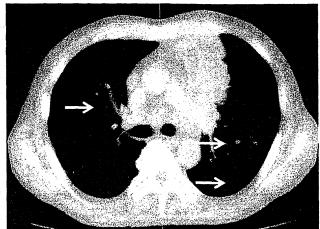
Computed tomography (CT) scan of the chest on admission to our hospital. Tumor in the left upper lobe, swelling of mediastinal lymph nodes, and small nodules in both lung fields and pleura (arrows).
